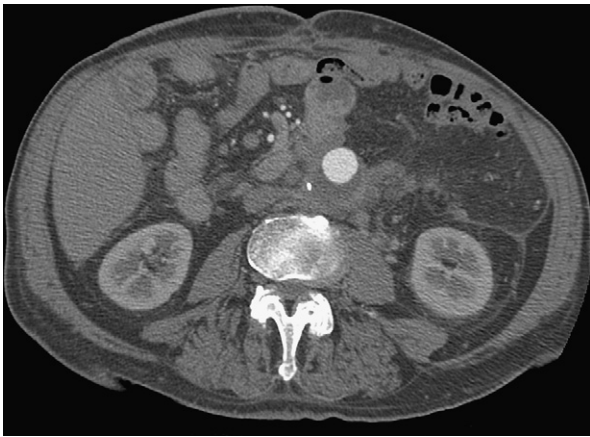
Postoperative CT-scan with spiral vein *in situ*.
